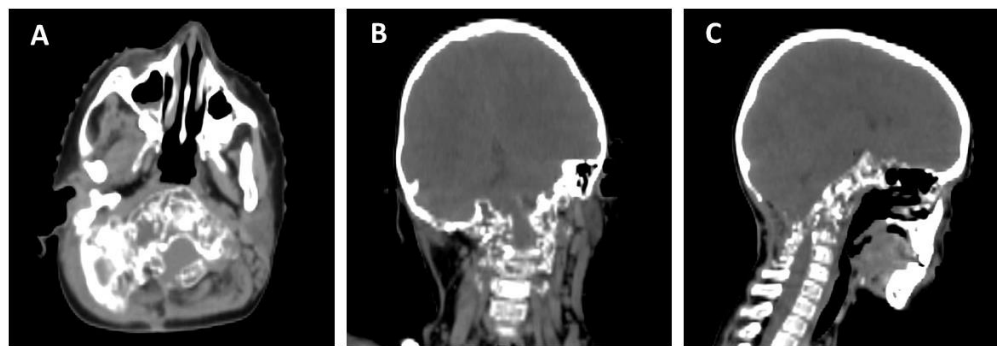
Computed tomography images taken before radiation therapy treatment. This figure shows three examples of computed tomography images obtained for radiation therapy planning. In axial view (A) we can observe a large osteolytic lesion over the petrous region of the temporal bone and the left occipital bone. The coronal view (B) shows osteolytic lesions of predominantly petrosal form bilateral with extrusion to the vertebral bodies of C1 and C2. The sagittal image (C) shows extensive osteolytic lesions in the clival region and the center of the occipital bone extending to the vertebral bodies and spinous apophysis of the first vertebrae.
